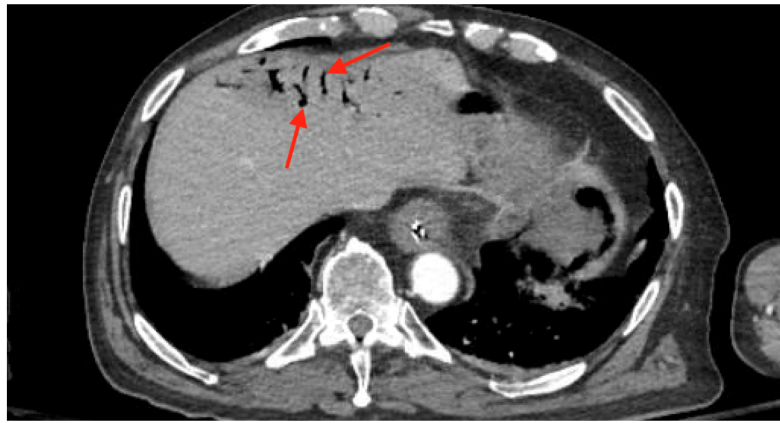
Contrast-enhanced CT with intravenous contrast. Axial section demonstrating hepatic portal venous gas, predominantly within the left hepatic portal venous system (arrows).
